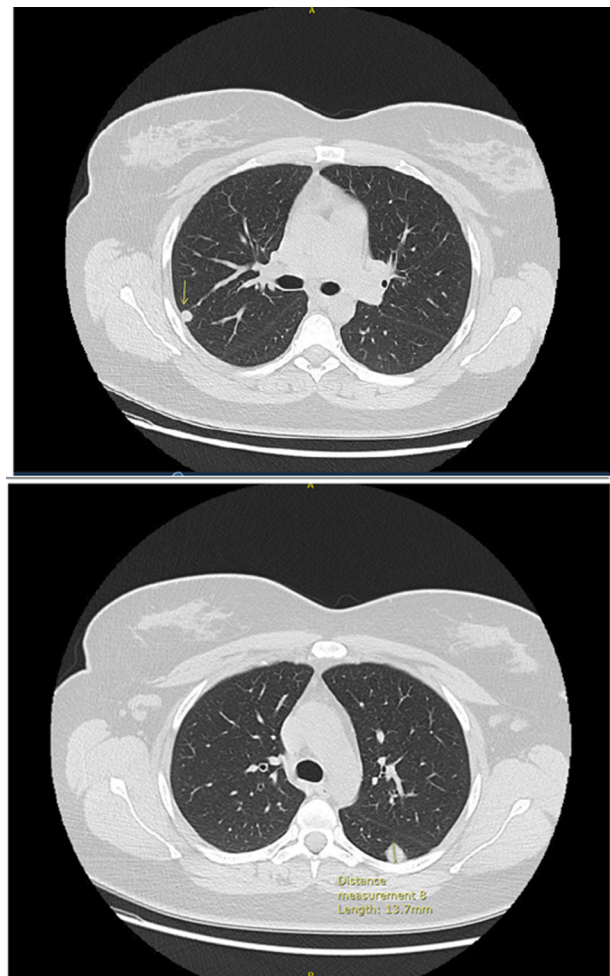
CT scan of the thorax showing multiple pulmonary nodules.
